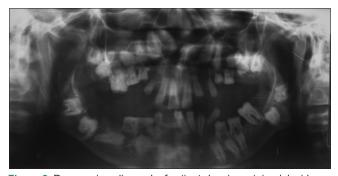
Panaromic radiograph of patient showing retained deciduous teeth and multiple impacted permanent teeth
